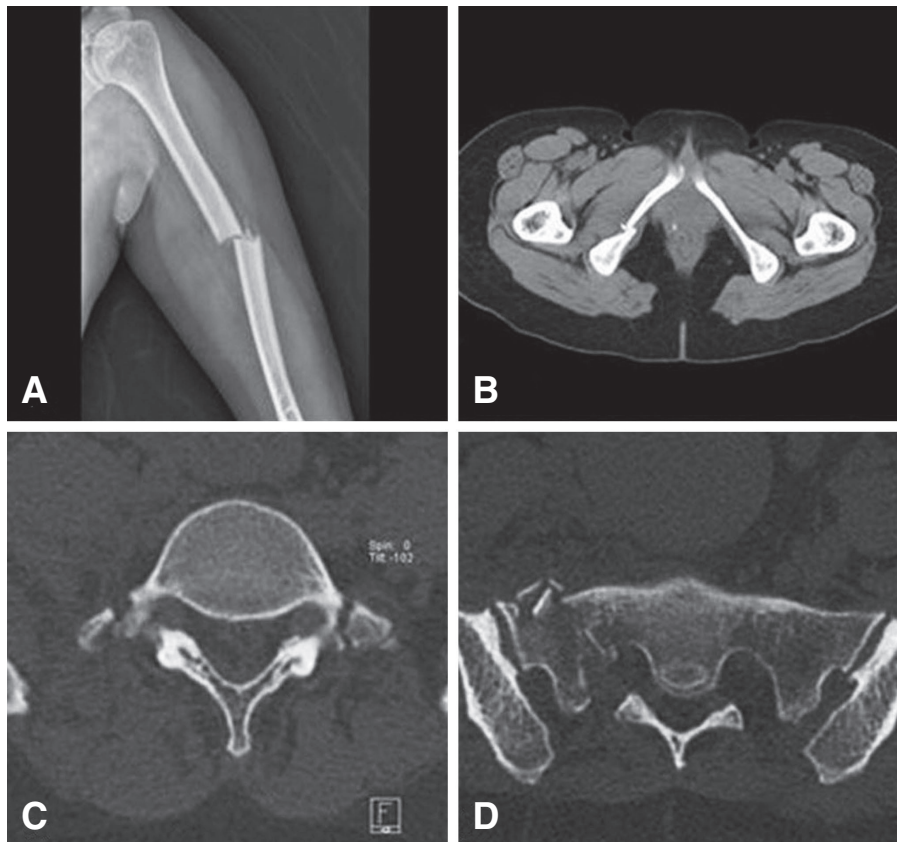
Initial radiologic images. (A) X-ray shows fracture on humerus shaft (B) CT shows fracture on pubic ramus of pelvic bone (C) CT shows fracture on both transverse process of lumbar vertebrae. (D) CT shows fracture on sacrum.
